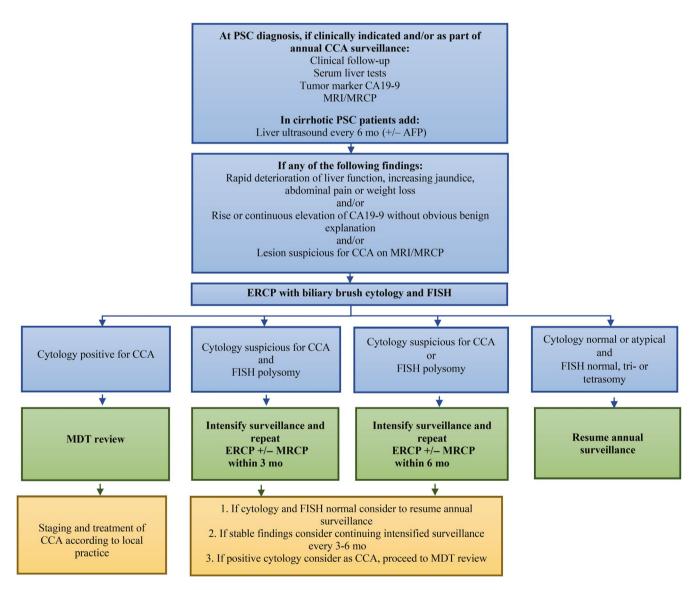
Suggested diagnostic evaluation of suspected cholangiocarcinoma (CCA) in patients with primary sclerosing cholangitis (PSC) The algorithm requires that ERCP with brush cytology and FISH assessments is available. In cases where insufficient biliary brush material is obtained at ERCP, a new ERCP procedure with biliary brushing needs to be considered to enable acquisition of sufficient material for diagnostic workup (cytology and FISH). Individual risk assessments are required in patients with cytology suspicious for CCA and/or polysomy after initial ERCP with brush cytology and FISH to determine the extent and frequency of further workup with new imaging, ERCP with brush cytology/FISH and possibly ductal biopsy. Abbreviations: PSC, primary sclerosing cholangitis; CCA, cholangiocarcinoma; CA19-9, carbohydrate antigen 19-9; MRI/MRCP, magnetic resonance imaging/magnetic resonance cholangiopancreaticography; AFP, alphafetoprotein; FISH; fluorescent in situ hybridization; ERCP, endoscopic retrograde cholangiopancreatography; MDT, multidisciplinary team
